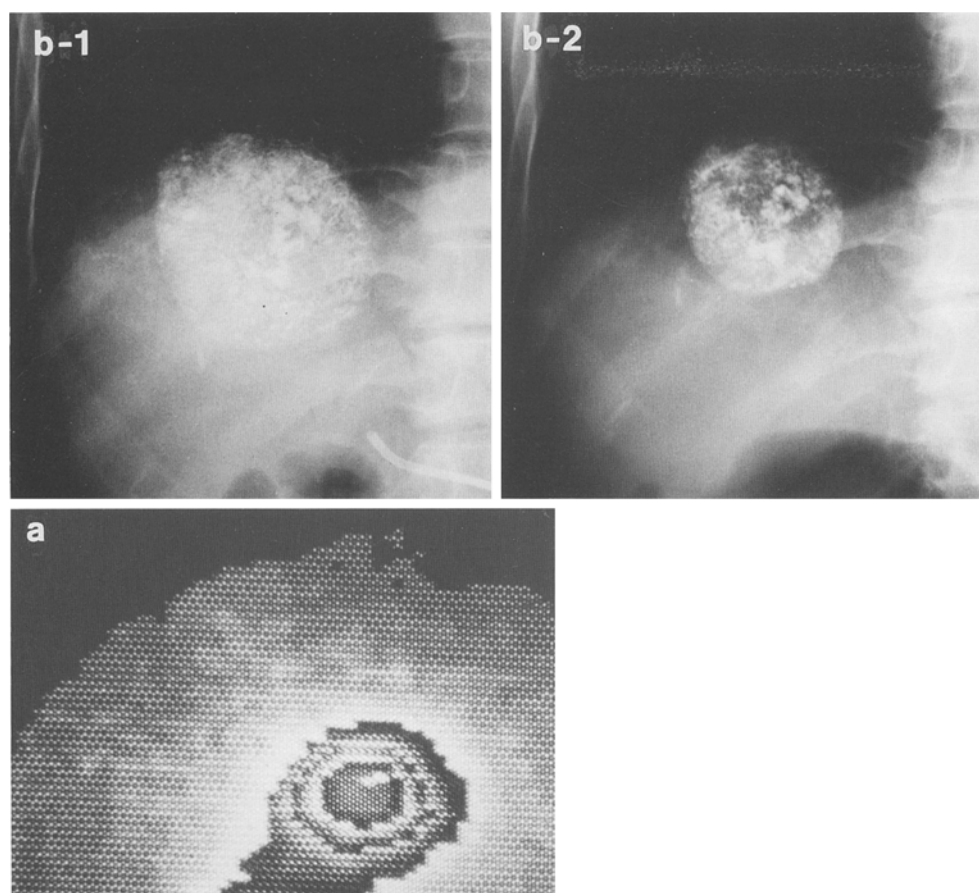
a, b. Patient 7. a A hepatic scintiphotograph prepared just after injection of [^{131}I]-Lp reveals a high accumulation of ^{131}I in the tumor. b Comparison of the plain upper abdominal radiograph obtained a few days after [^{131}I]-Lp injection (b-1) and that obtained 5 months later (b-2) shows that the tumor has decreased considerably in size
